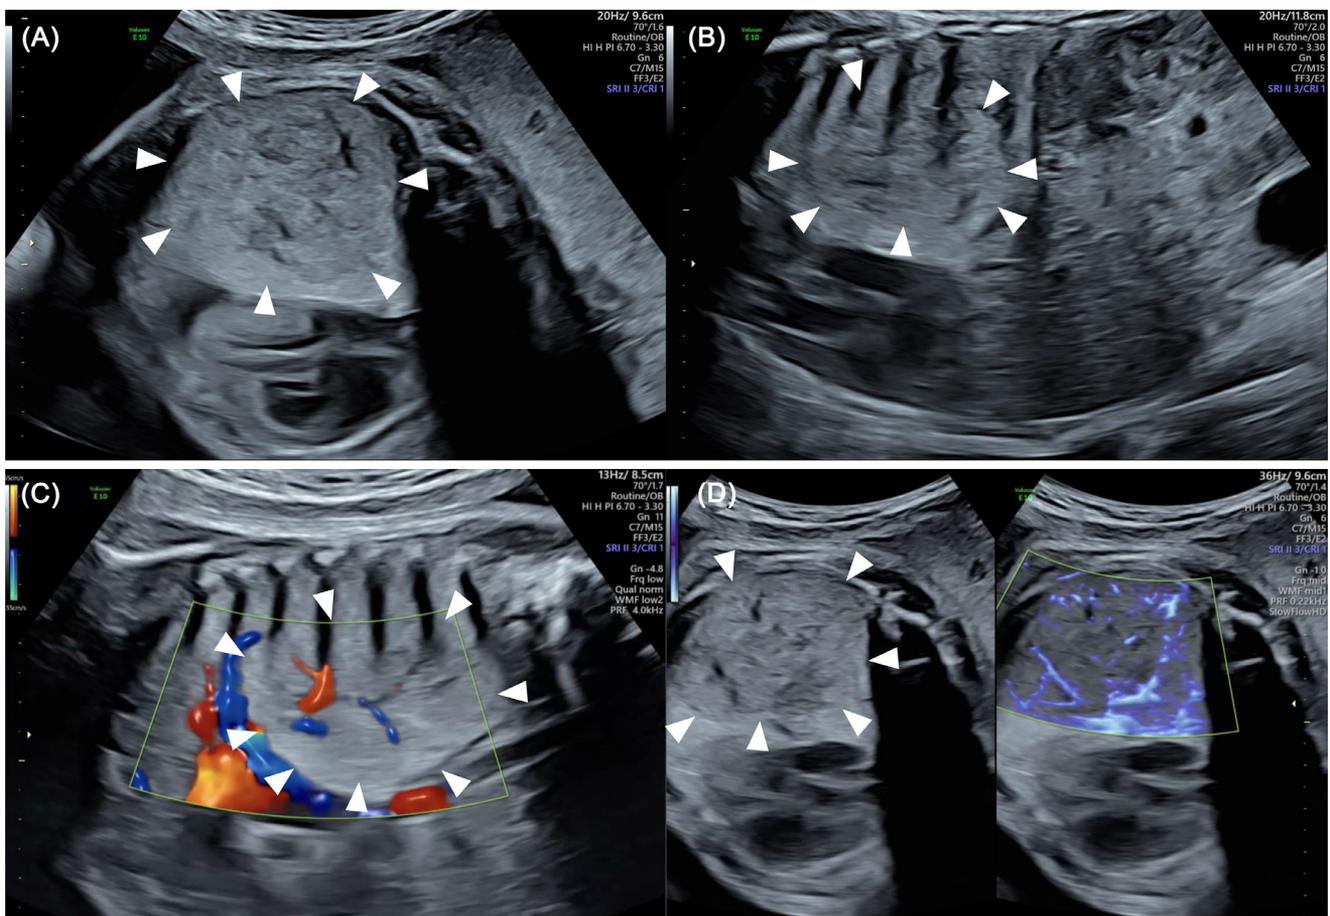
Fetal ultrasonography at 33 gestation weeks. Transverse (A) and sagittal (B) ultrasound sections demonstrate a heterogeneous lung lesion (arrowhead). Color Doppler (C) and SlowflowHD mode (D) showed blood flow within the tumor (arrowhead). The SlowflowHD mode allowed clear visualization of the microvascular flow in the tumor.
